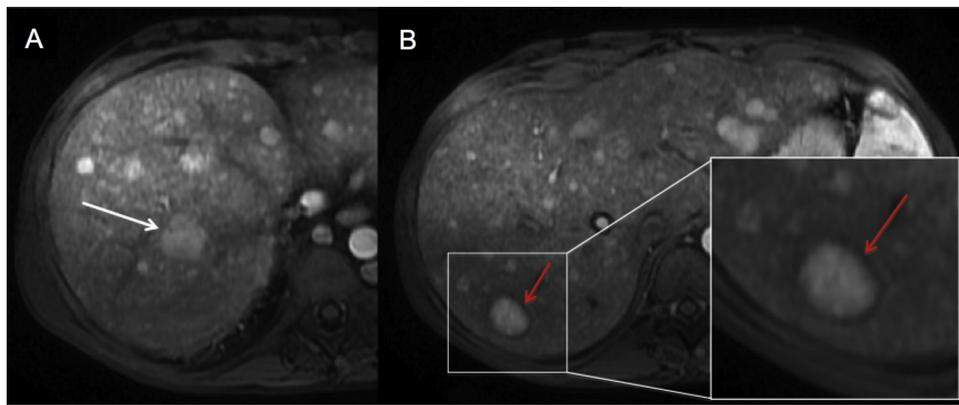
Arterial phase imaging. FNH-like RNs are typically hyperintense on arterial phase MR images, showing homogeneous marked enhancement (white arrow) (a). A hypoattenuating ring (red arrow) may be seen surrounding some of the lesions (b).
